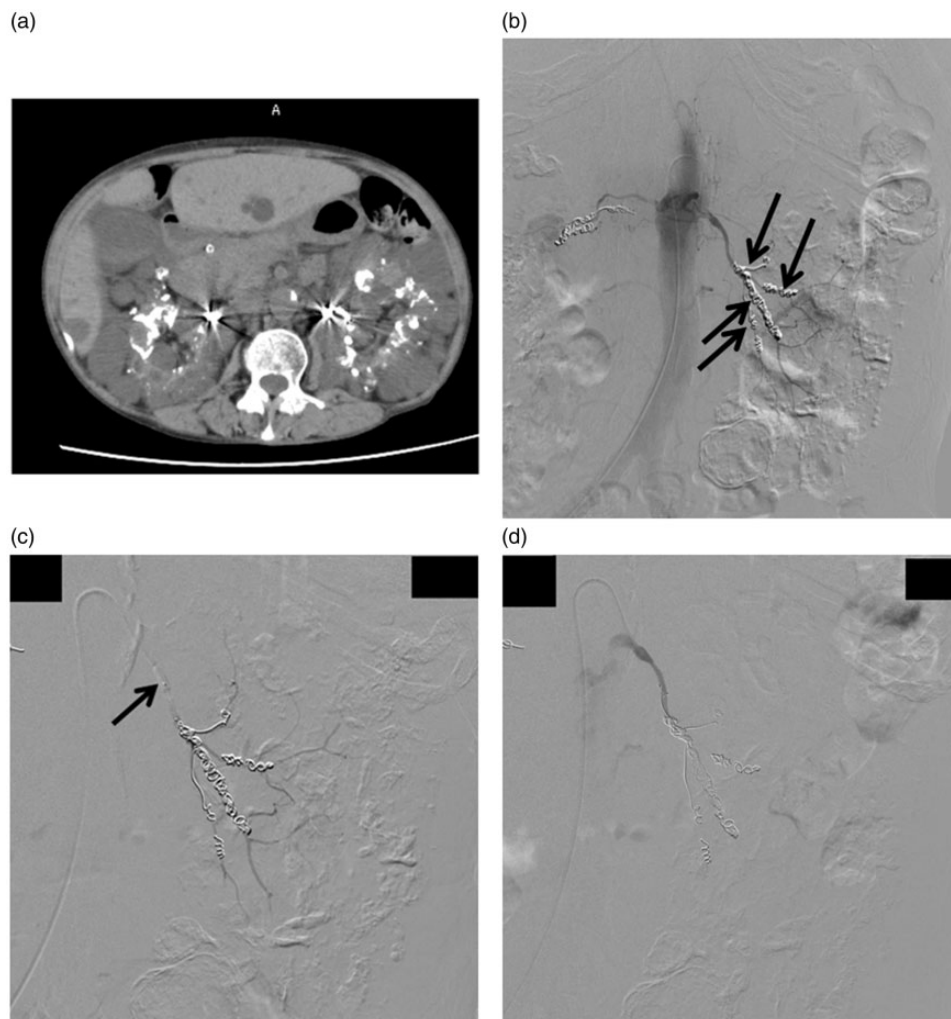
A woman in her 60s with ADPKD. (a) Enhanced abdominal CT image shows enlarged polycystic kidneys on both the right and left side. (b) Left renal arteriography shows re-canalization of the renal arterial branches previously embolized with microcoils (arrows). Note reflux of contrast agent to the aorta. (c) Arteriography obtained while micro-balloon (arrow) positioned at the origin of the left renal artery was inflated clearly shows renal arterial branches at the distal segments beyond microcoils. Note that no reflux is seen. (d) Left renal arteriography after embolization procedures shows no visualization of renal arterial branches.
